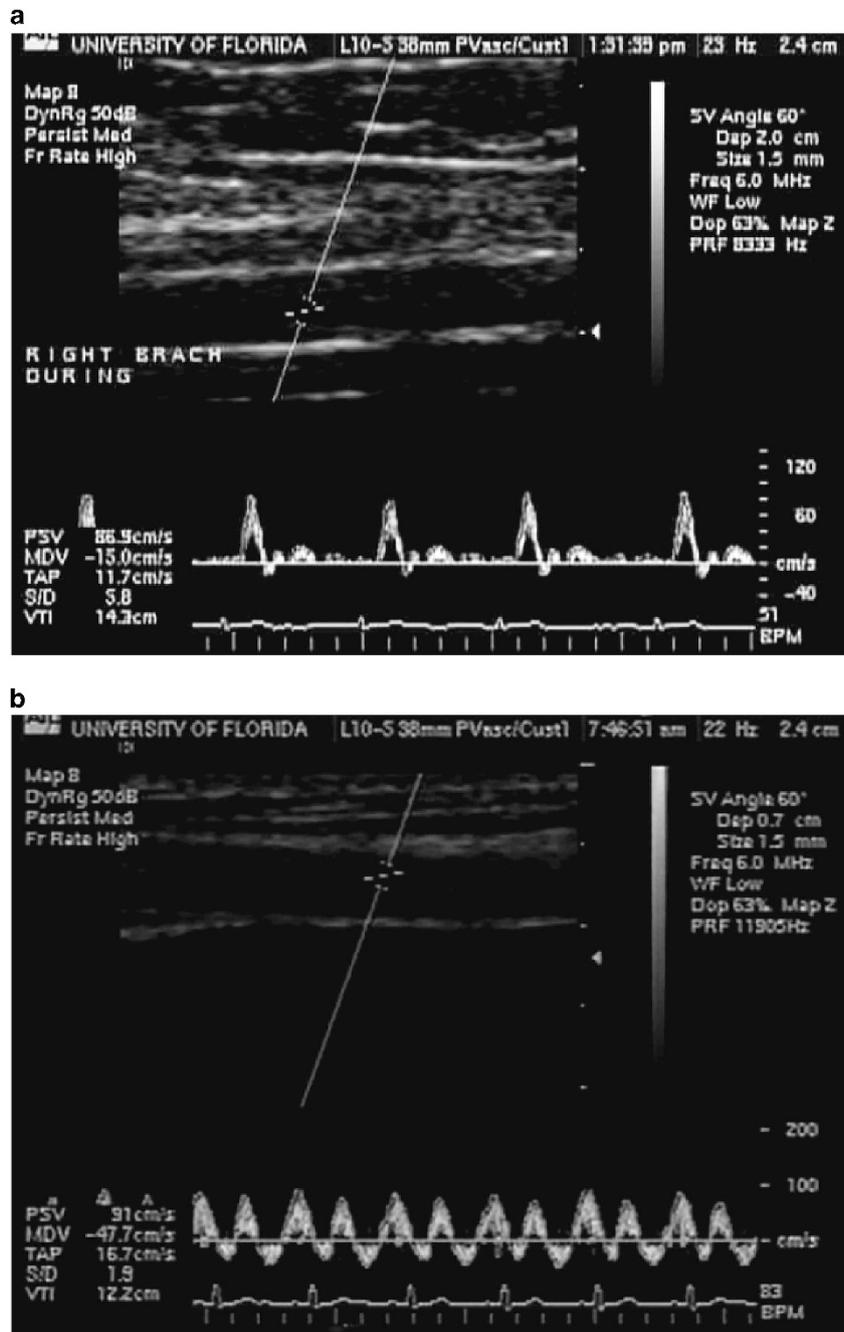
Ultrasound pictures and Doppler spectrum of the brachial artery during Sham (a) and EECP (b).
